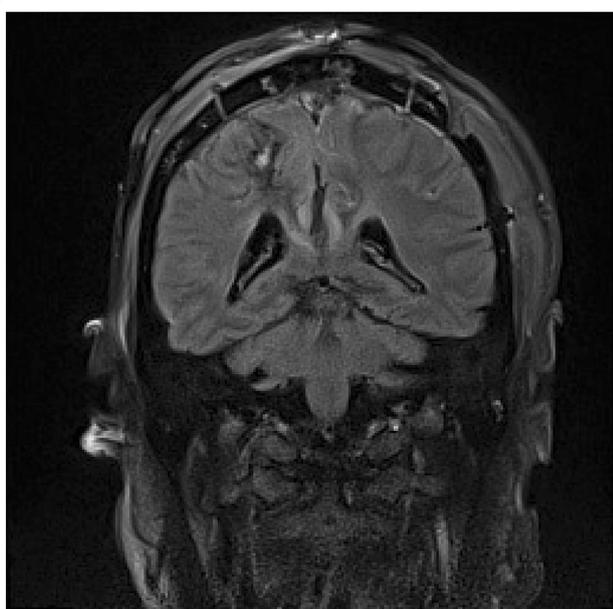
FLAIR coronal image, 48 h post-surgery. Focal left posterior parietal lobe edema with additional areas of edema and sulcal effacement seen along the paramedial parieto-occipital lobes
